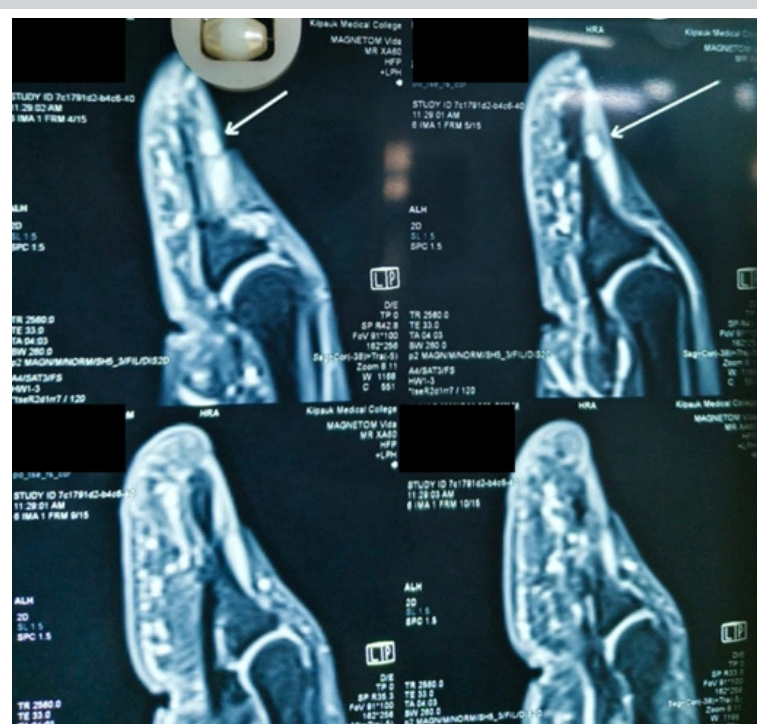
Magnetic resonance imaging demonstrating subungual lesion with T1 hypointensity and T2 hyperintensity.
